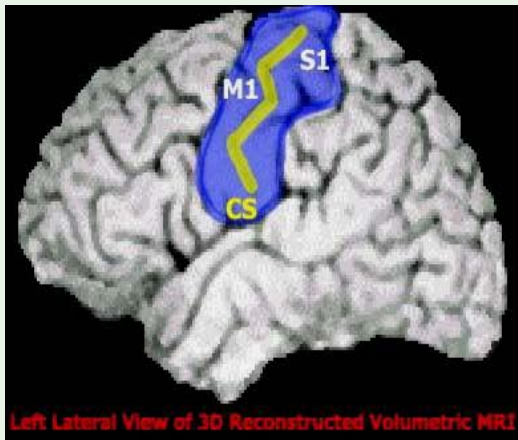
(a): Anatomical Measure of the Anterior Bank of the Central Sulcus: The measure of the anterior bank of the Central Sulcus (CS) is depicted on a three-dimensional MRI reconstruction of the lateral surface of the left cerebral hemisphere, and the ROI is outlined.
